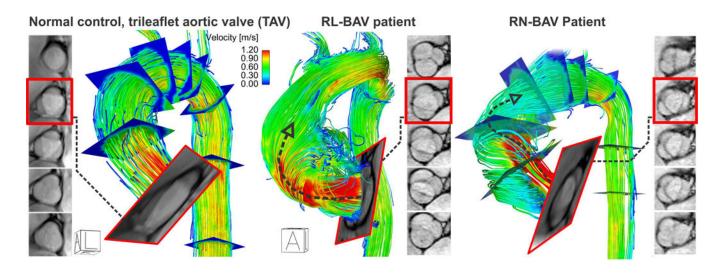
4D flow MRI of BAV-mediated hemodynamics
